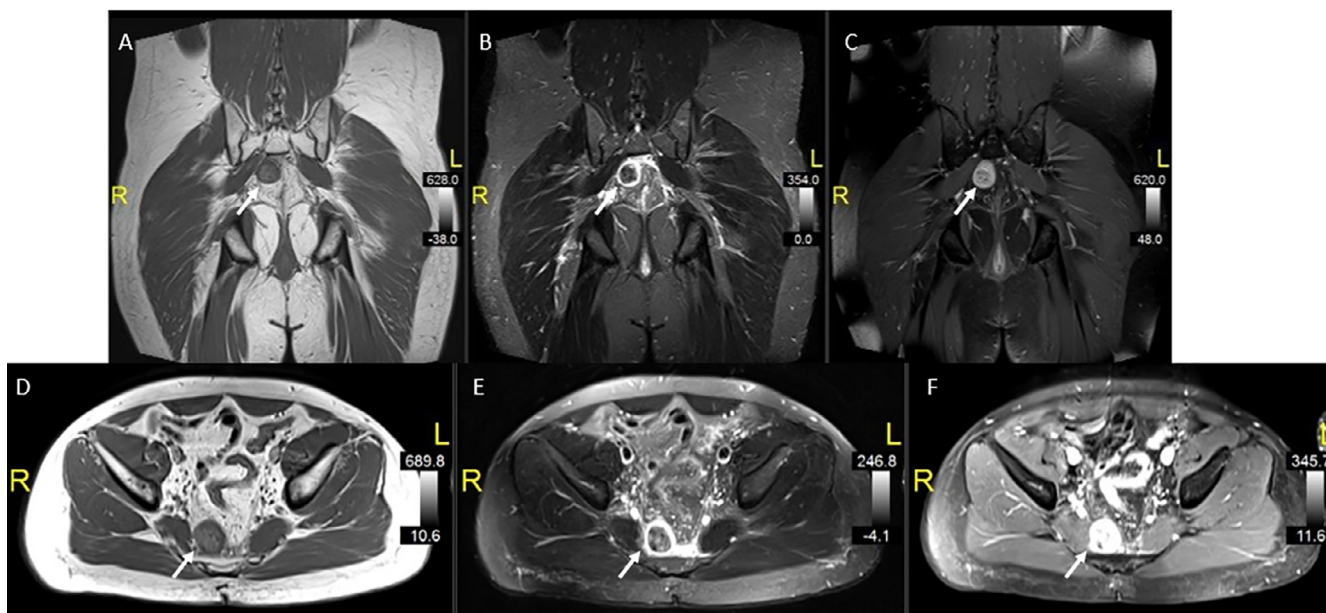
Magnetic resonance imaging showing a soft tissue mass (arrow) hypointense in T1 (A,D), with peripheral hyperintensity on STIR (B,E) and with gadolinium heterogenous enhancement (C,F).
